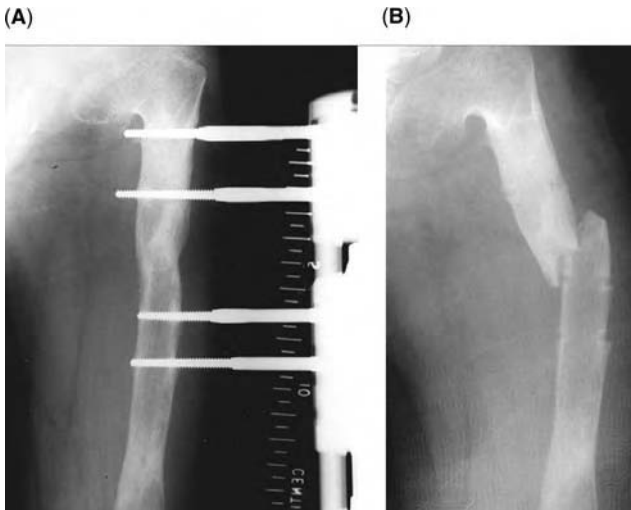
Radiographs of a child with a congenitally short femur after bifocal lengthening showing (A) good consolidation and (B) a fracture through the regenerate. *Source:* From Ref. 1.
